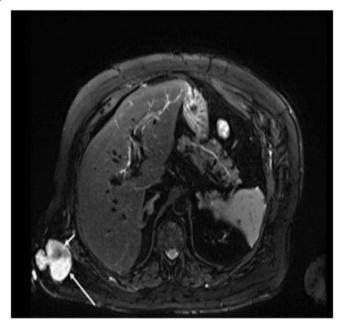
Postcontrast T1-weighted image reveals enhancement of the mass (long arrow), sparing the central part (short arrow).
